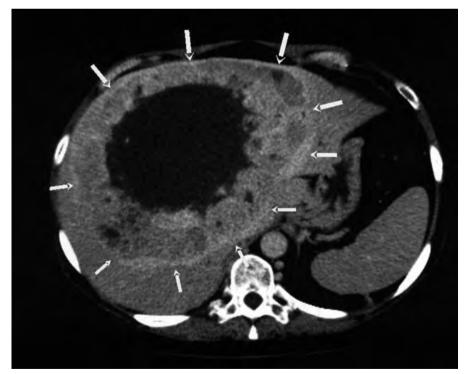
CT scan with contrast. Predominantly hypodense central image with contrast capture and peripheral nodular enhancement (arrows), occupying the central two thirds of the liver.
